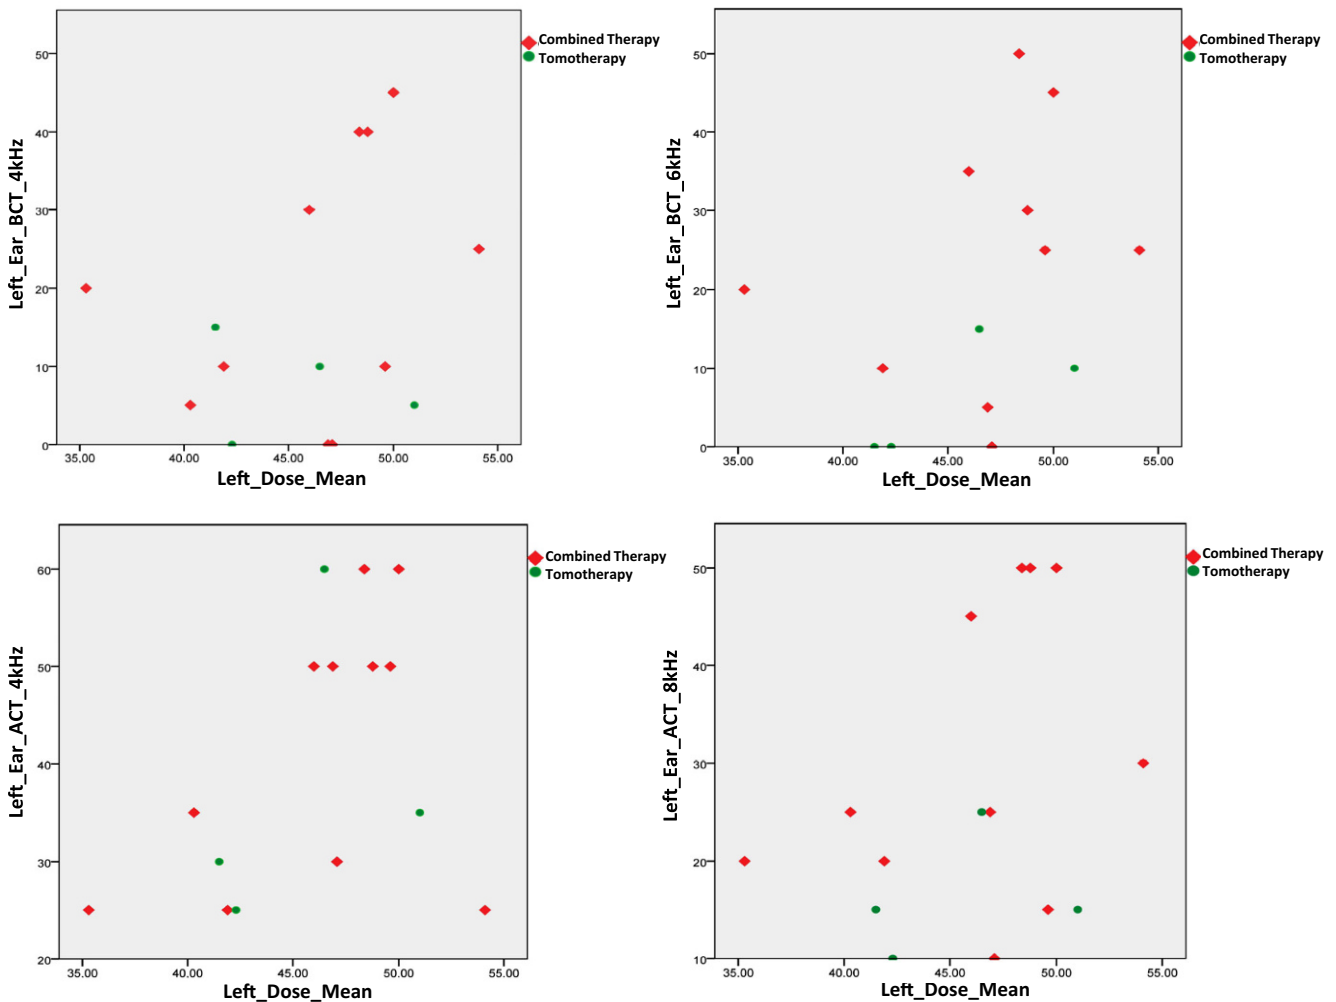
Dot plot of hearing thresholds in mid-high and high frequencies in the left ear at latest follow-up with conventionally fractionated tomotherapy vs. combined technique. *SNHL* sensorineural hearing loss, *Tomo/CRT* tomotherapy/once-daily fractionation, *CT/CRT* combined technique/once-daily fractionation, *Tomo/HRT* tomotherapy/twice-daily fractionation, *CT/HRT* combined technique/twice-daily fractionation, *BCT* bone-conduction threshold, *ACT* air-conduction threshold
